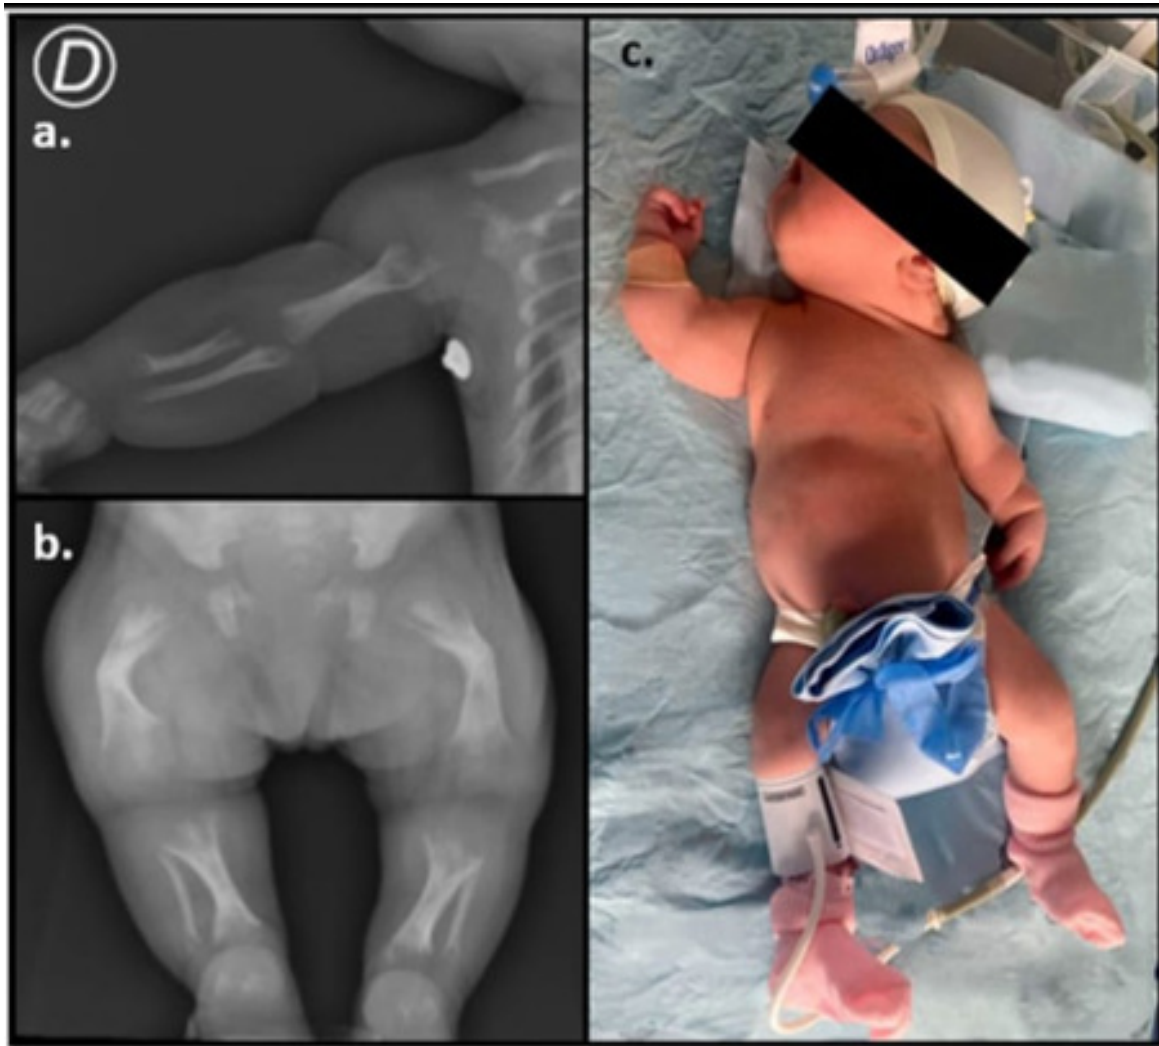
X-RAY OF THE EXTREMITIES IN NEWBORNS: A. WIDENING AND LACK OF OSSIFICATION OF THE METAPHYSES AND PROXIMAL EPIPHYSES OF THE HUMERUS, RADIUS, AND ULNA; DECREASED BONE DENSITY. B. WIDENING AND ABSENCE OF OSSIFICATION OF THE METAPHYSES AND PROXIMAL EPIPHYSES OF THE FEMUR, TIBIA, AND FIBULA; CURVATURE OF THE MID-SHAFT OF THE FEMUR (WHITE ARROWS); DECREASED BONE DENSITY. C. PHENOTYPIC MANIFESTATIONS OF A NEWBORN WITH PRENATAL HYPOPHOSPHATASIA.
